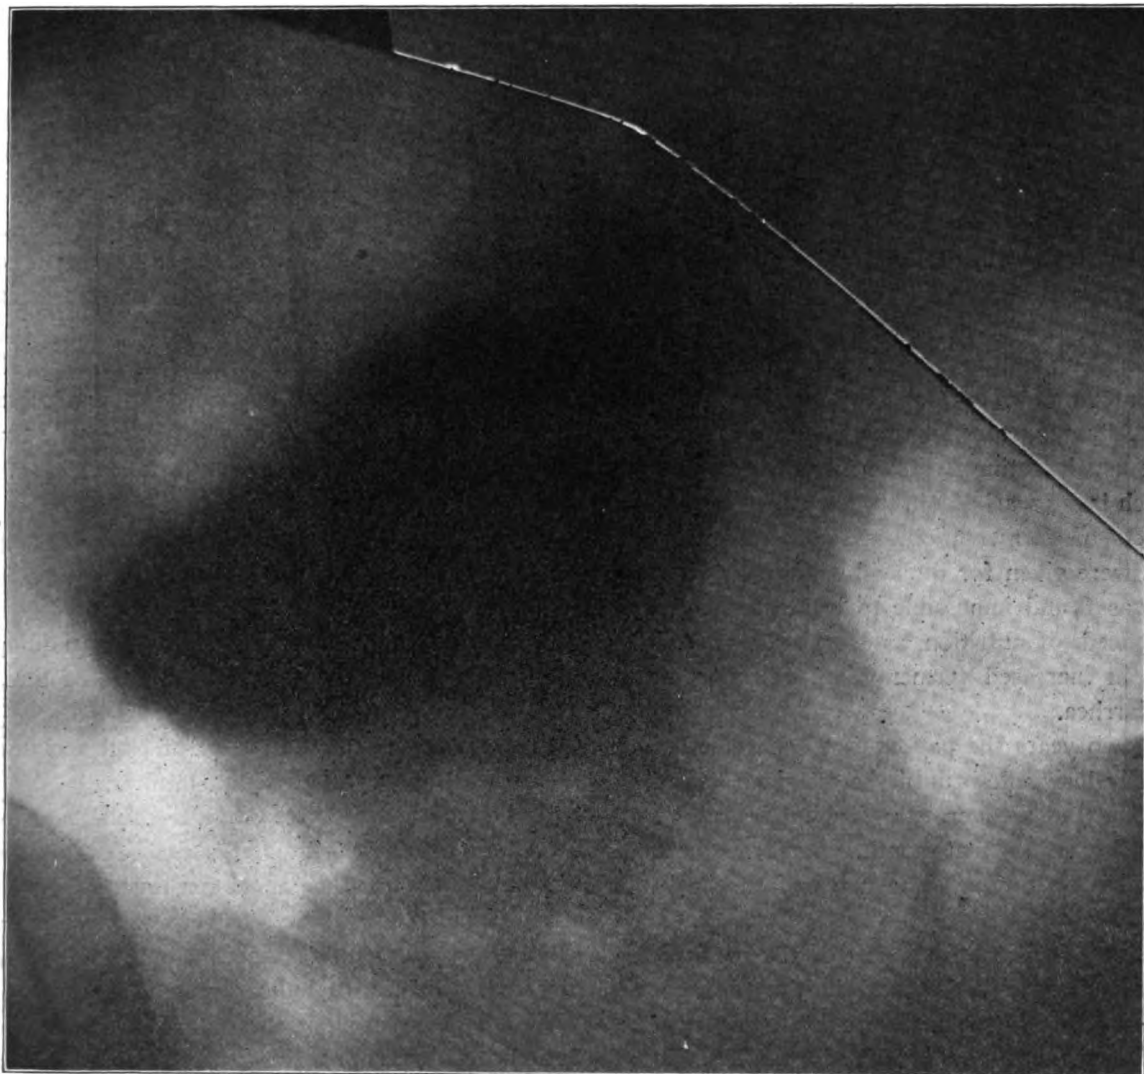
Radiograph of the stomach one month after operation, taken in the erect position.
